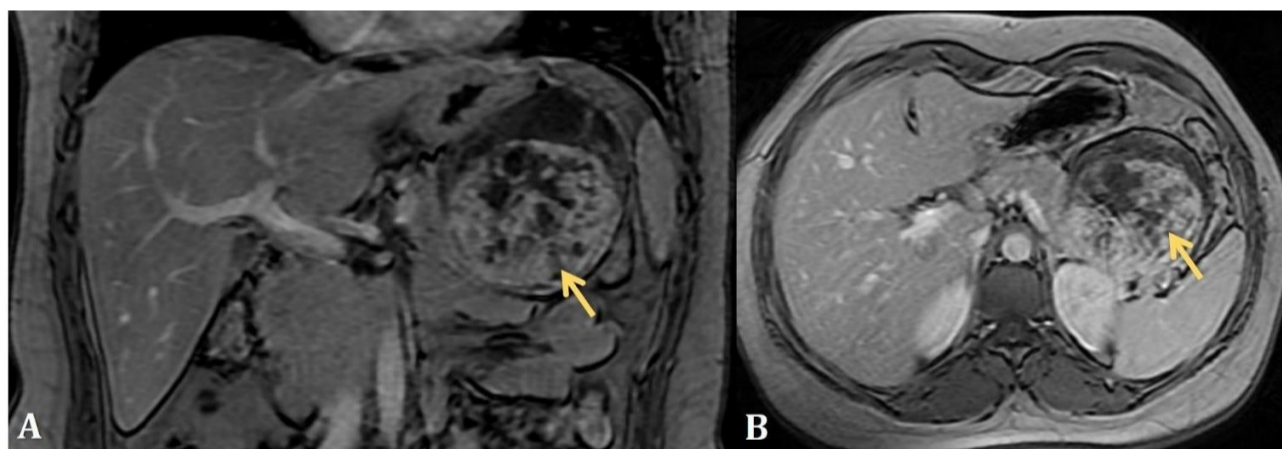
Coronal (A) and axial (B) T1 FAT SAT post contrast abdominal MRI images showing theenhancement of the solid component (yellow arrow).
